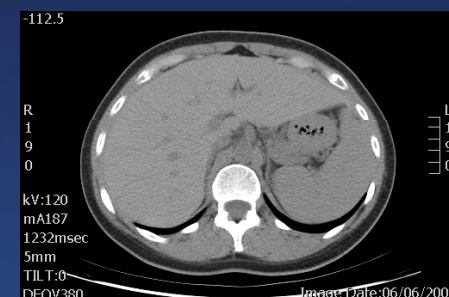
Normal CT demonstrating no HPVG
